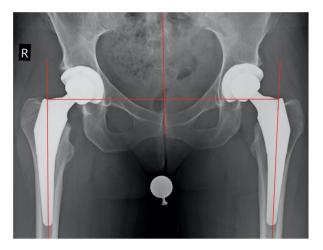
The method used to calculate combined offset measurement on AP pelvis radiograph.
